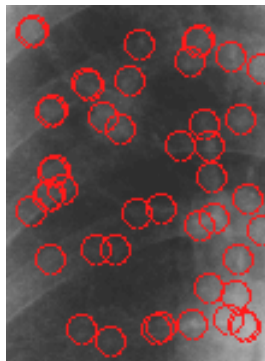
The original radiograph (a) was zoomed in on the specified region (b).
